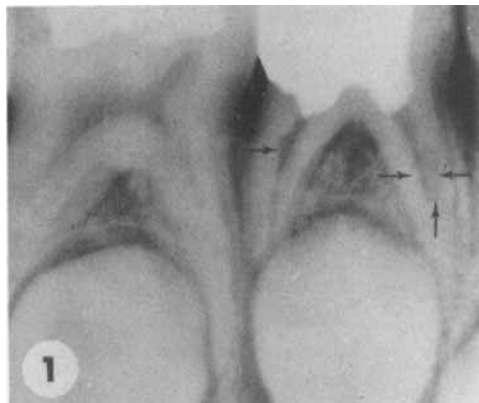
Radiograph of a lower first molar 7 months after pulpotomy with the formocresol technique. Moderate internal root resorptions in both roots (arrows).
